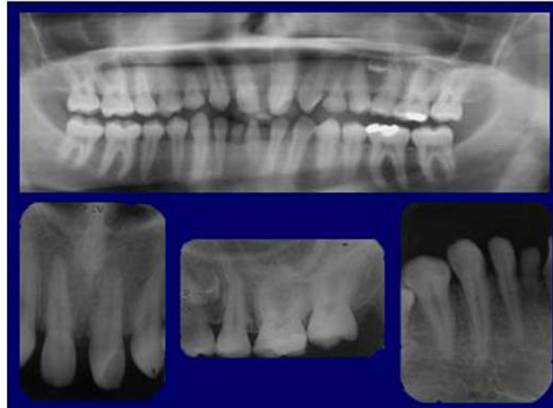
Panoramic and periapical radiographs of the patient showing the concomitant hypo-hyperdontia
